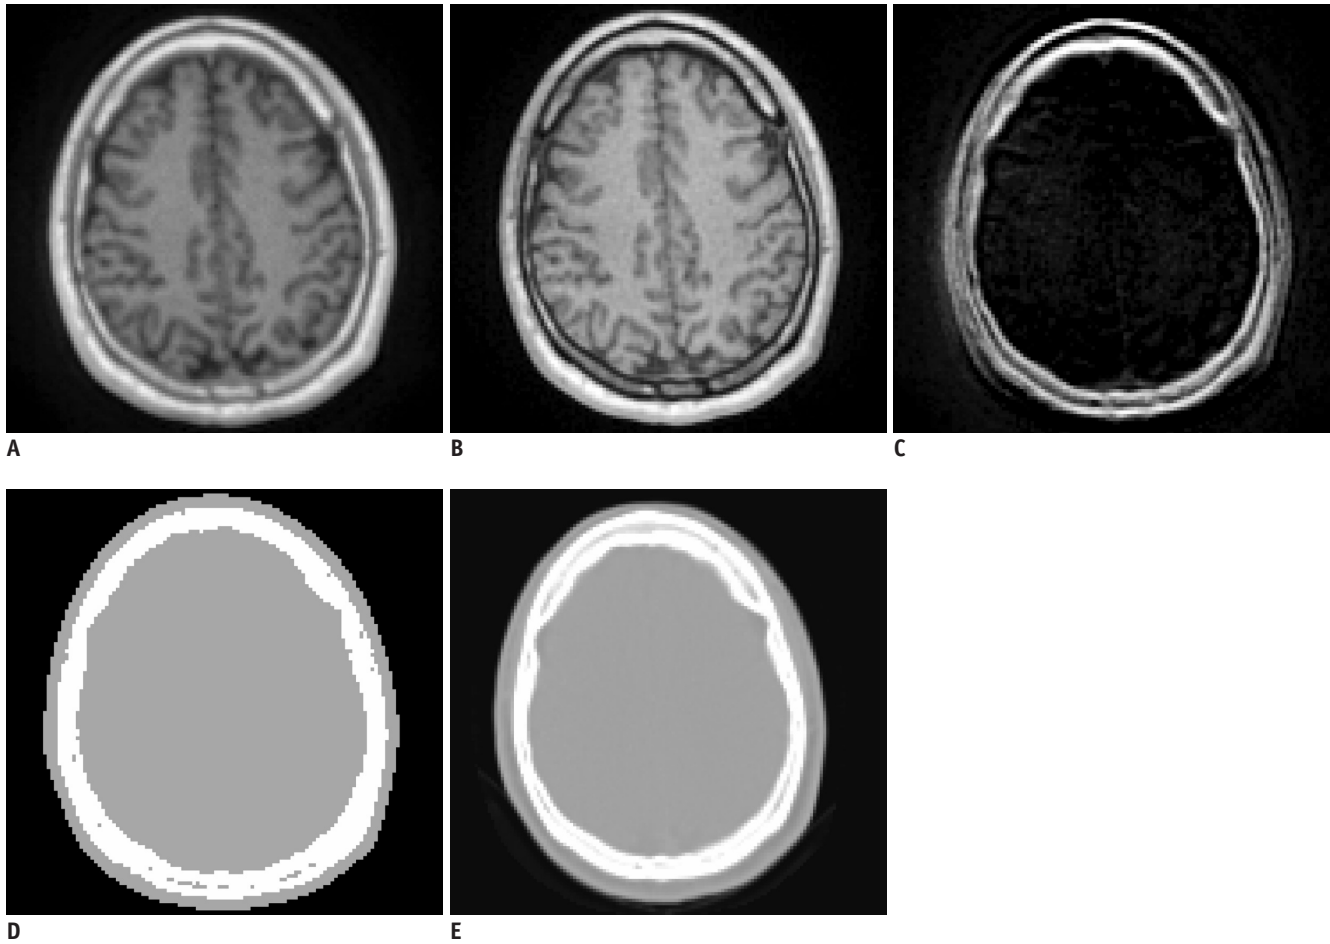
Ultrashort echo time (UTE) MRI-based attenuation correction. MR images acquired at first (A) and second (B) echo times (echo time = 0.07 ms and 2.46 ms, respectively). C. Differential image of A and B. D. UTE-based attenuation map. E. CT of same patient.
